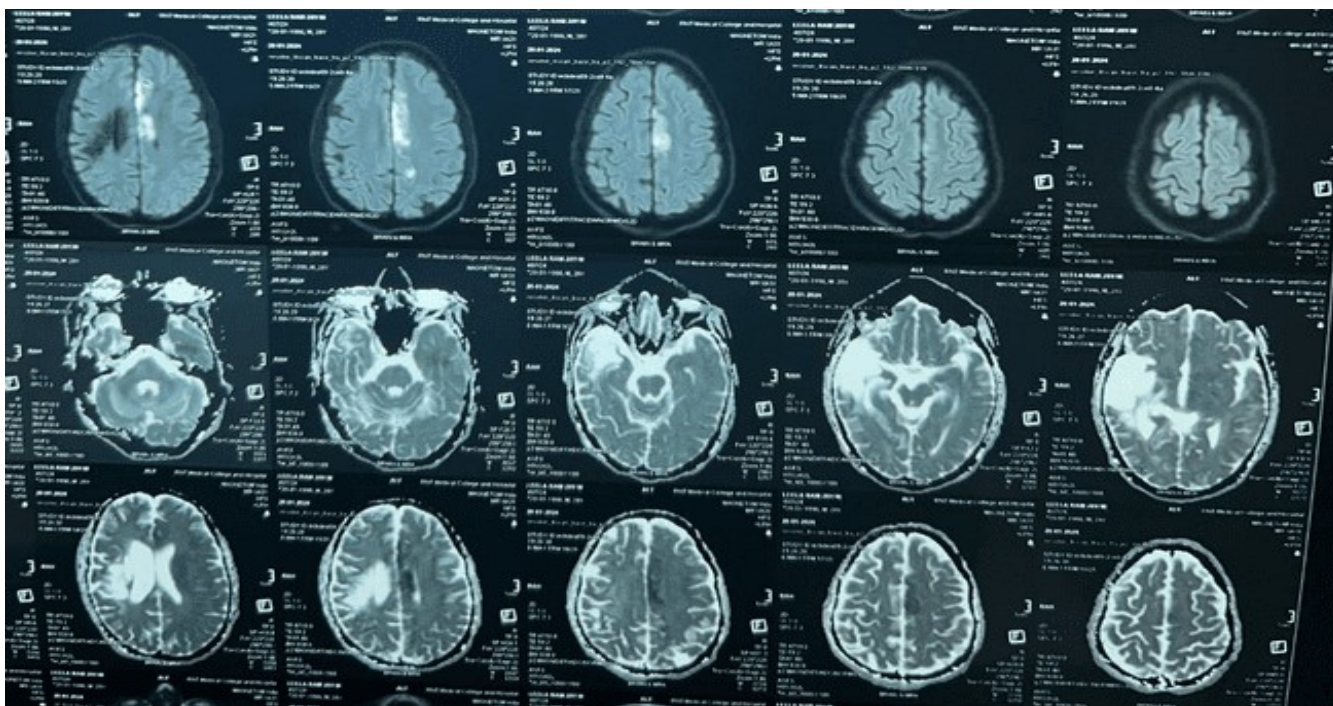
MRI. T2W hyperintensity in right frontoparieto temporal region in parafalcian location with FLAIR hypointense in right frontoparieto-temporal region
